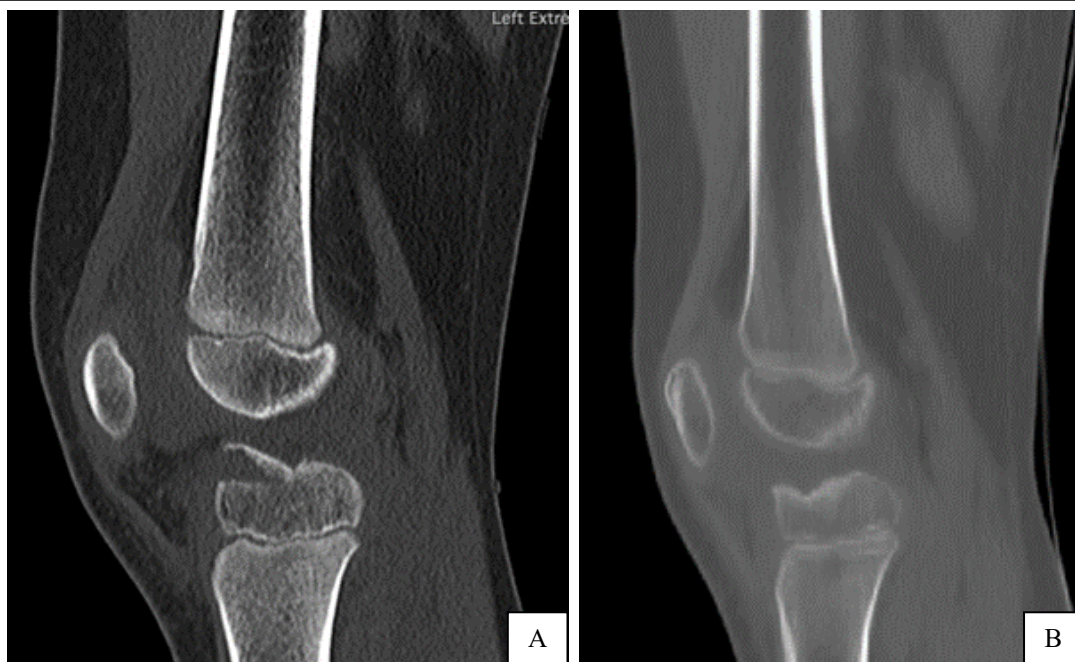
A Preoperative CT scan demonstrating displaced tibial spine fracture in 6 years old girl. B - Postoperative CT scan at 6 months follow-up demonstrating good integration of avulsed fragment.
